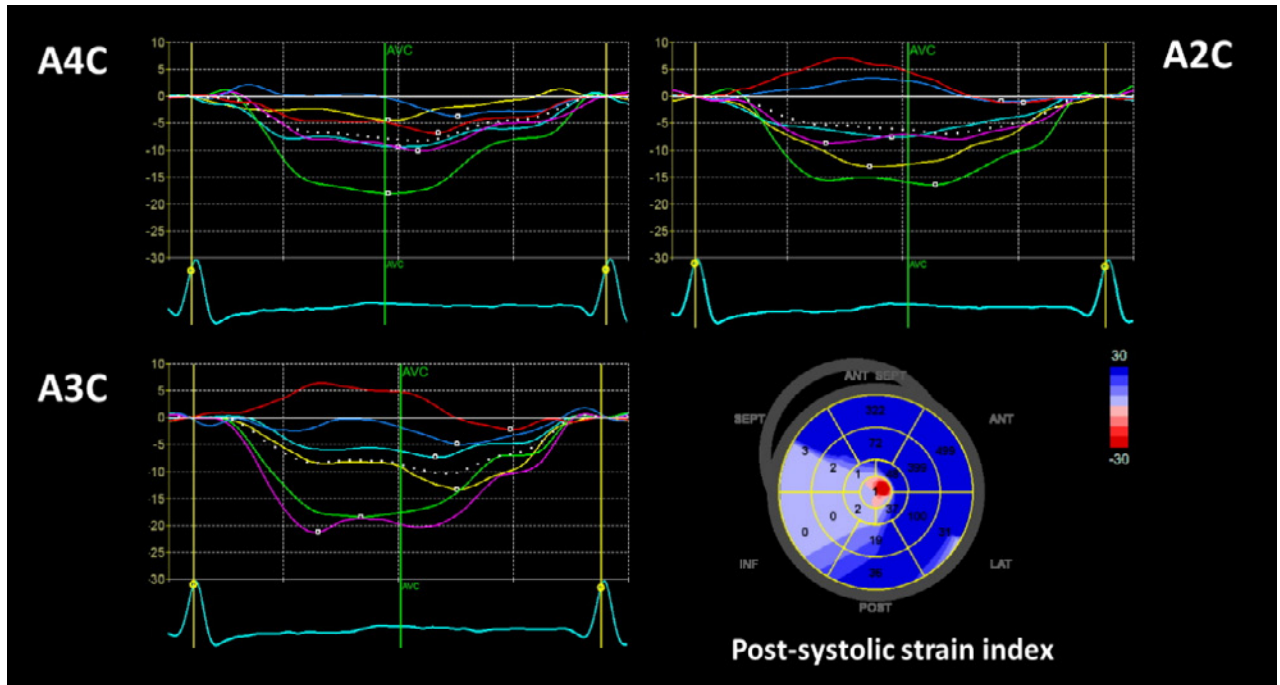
This figure shows strain-time curve of 3 apical views (A3C = apical 3 chamber view; A4C = apical 4 chamber view; A2C = apical 2 chamber view) in 1 cardiac cycle and bullseye mapping of post-systolic strain index. There were several segments of myocardium showing delayed peak-systolic strain after aortic valve closing (AVC) from the strain-time curves. Post-systolic strain index is defined as peak post-systolic longitudinal strain – end-systolic strain / end-systolic strain (%). Bullseye mapping of post-systolic strain index shows markedly increased post-systolic shortening in Case 2. Blue color represents post-systolic shortening.
